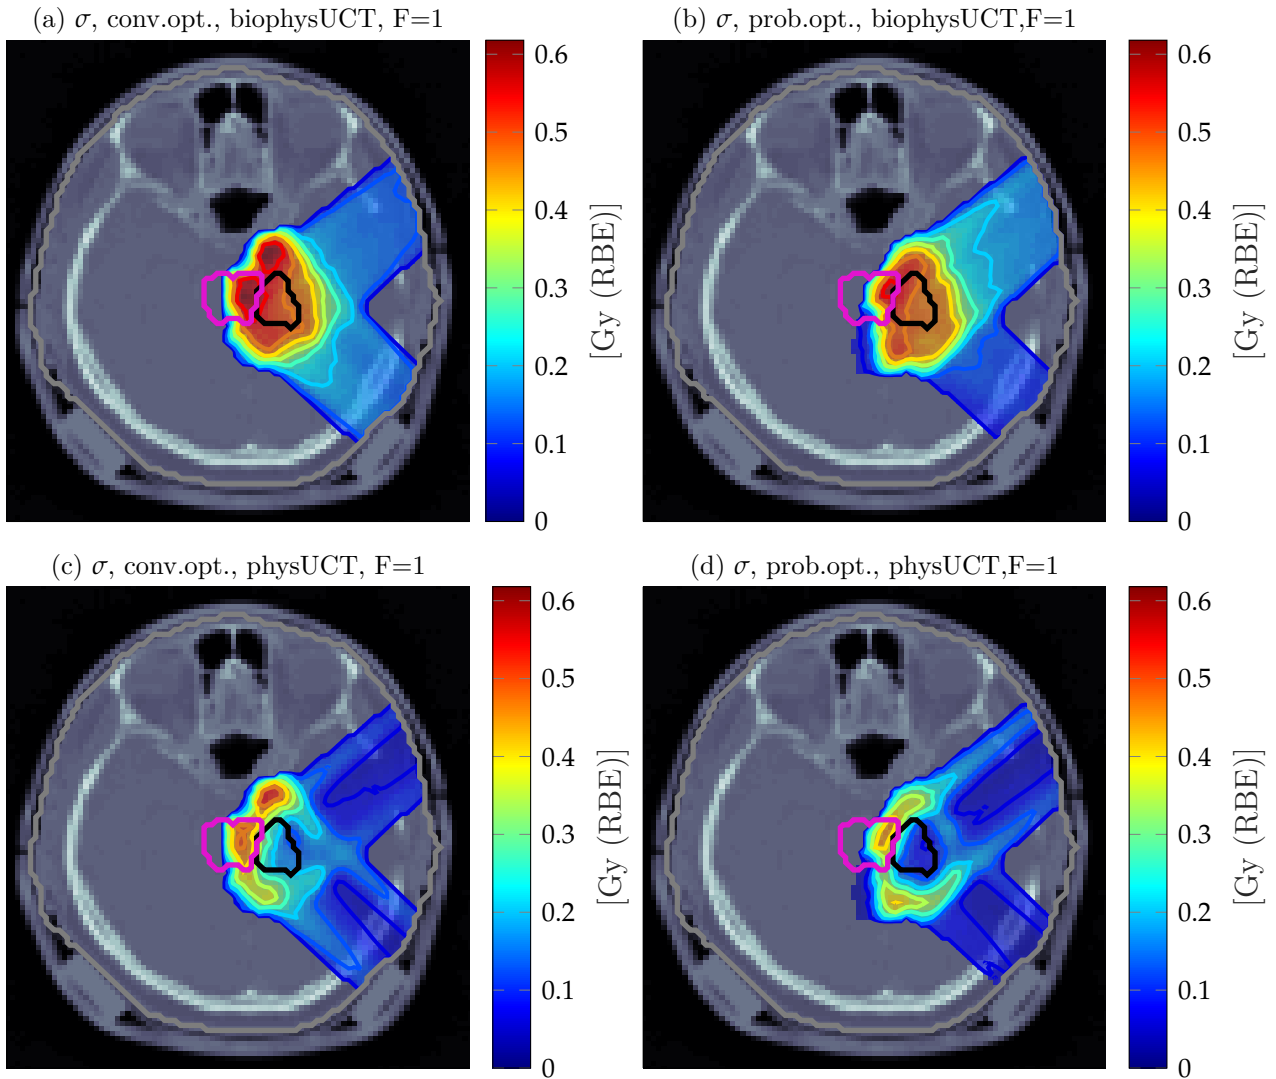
Transversal CT image with transparent dose colorwash, solid contours and solid isodose lines showing $\sigma[RBE \times d]$ based on conventional optimization and a single fraction in (a). Complementary highlights (b) $\sigma[RBE \times d]$ based on probabilistic optimization for 20 fractions but for uncertainty quantification also a single fraction is considered.
